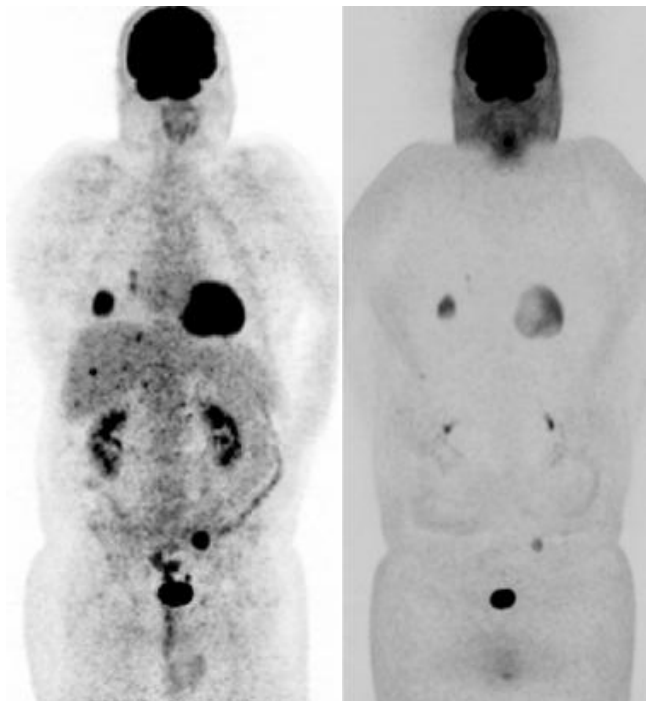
Metastatic disease. FDG PET/CT maximum intensity projections (MIP, PET-only). Left: CT attenuation corrected PET images. Right: Non-attenuation corrected PET images. Left and right: The CT attenuation corrected images show more malignant lesions and more intense uptake in the lesions compared to non-attenuation corrected images.
